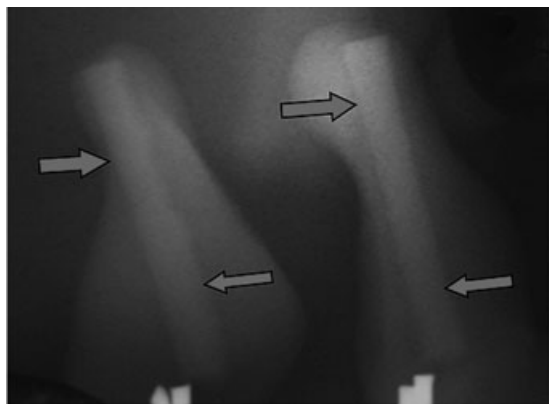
A radiograph of the nasal stent shows the putty ropes.
